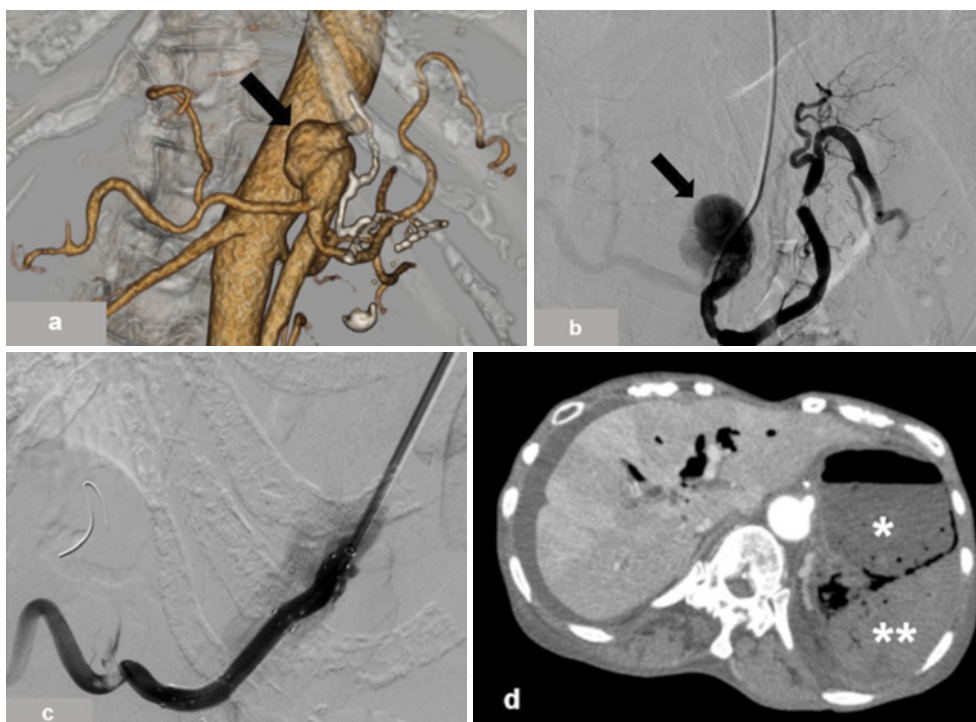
Early mortality following SG placement in a 76-year-old woman with a history of pancreaticoduodenectomy for duodenal papilla carcinoma 3 years earlier and distal gastrectomy for gastric cancer 13 years prior. (a) The 3D reconstruction of the CT image and (b) DSA discovered a 3.0-cm pseudoaneurysm in the celiac artery (black arrow). (c) Two Viabahn SGs (6 mm and 5 cm) were placed from the common hepatic artery to the celiac artery, following 8-mm AVP-4 insertion in the splenic artery to prevent type 2 endoleak. Celiac arteriography revealed the disappearance of the pseudoaneurysm and thrombus in the proper hepatic artery, resulting in reduced blood flow in the left hepatic artery. The clearance of this thrombus was verified through postoperative CT with no further therapy. (d) Contrast-enhanced CT 2 days following SG installation showed necrosis of the stomach (*), spleen (), and pancreas (not shown), which were thought to be related with SG placement. The patient died 6 days after SG installation.
